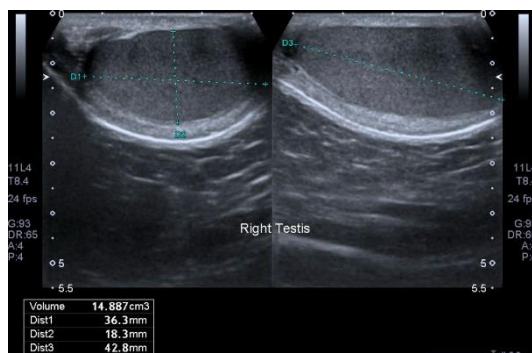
Testicular volume assessed by ultrasonography.
